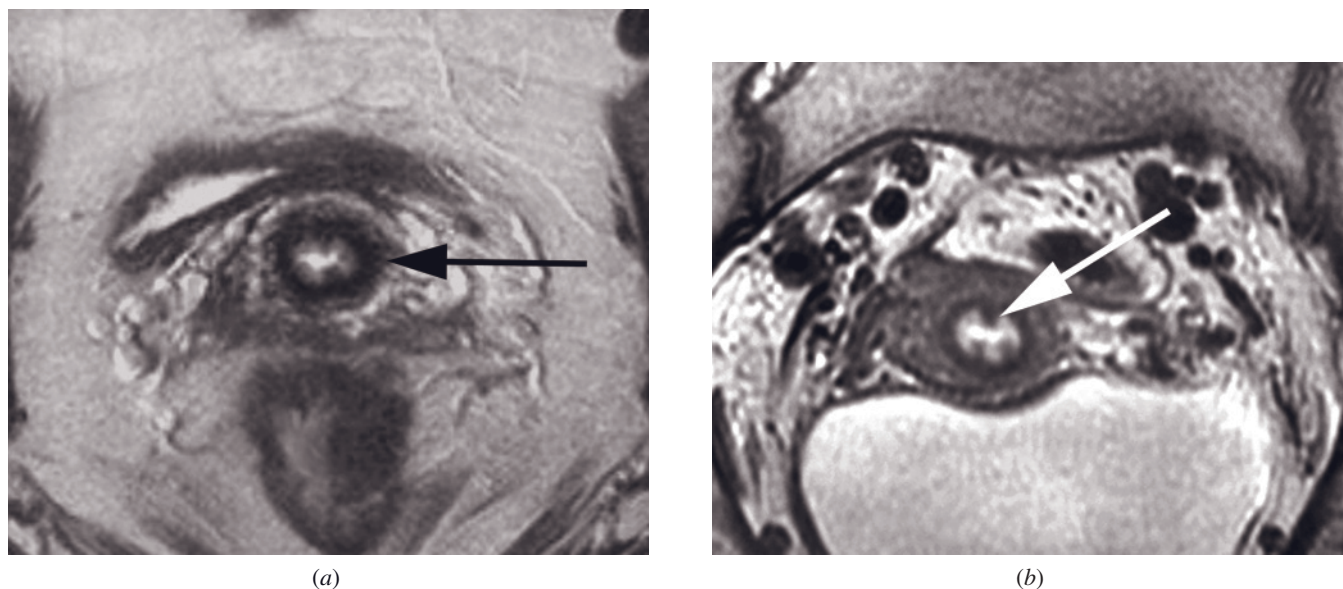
Short-axis view of the cervix. (a) T2-weighted ETSE image perpendicular to the endocervical canal shows the cervical zonal anatomy: central hyperintense mucus, high signal-intensity mucosa, hypointense fibrous stroma (arrow), and outer intermediate-signal-intensity loose stroma. Short-axis view of the cervix at 3T. T2-weighted ETSE image (b) perpendicular to the endocervical canal in a different patient shows the cervical zonal anatomy including prominent vertical folds (arrow) due to plicae palmatae.
